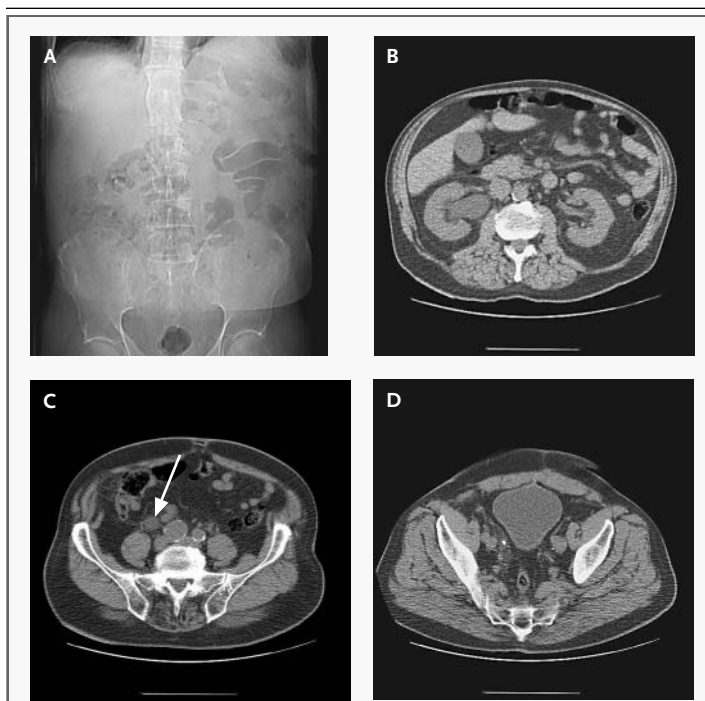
Plain Abdominal Radiography (Panel A) and Helical CT (Panels B, C, and D) in a 68-Year-Old Man with Nausea and Severe, Colicky Pain in the Right Lower Quadrant Radiating to the Tip of the Penis.
